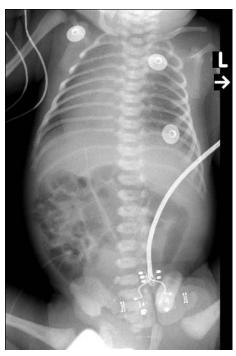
Dextrocardia in roentgen picture
